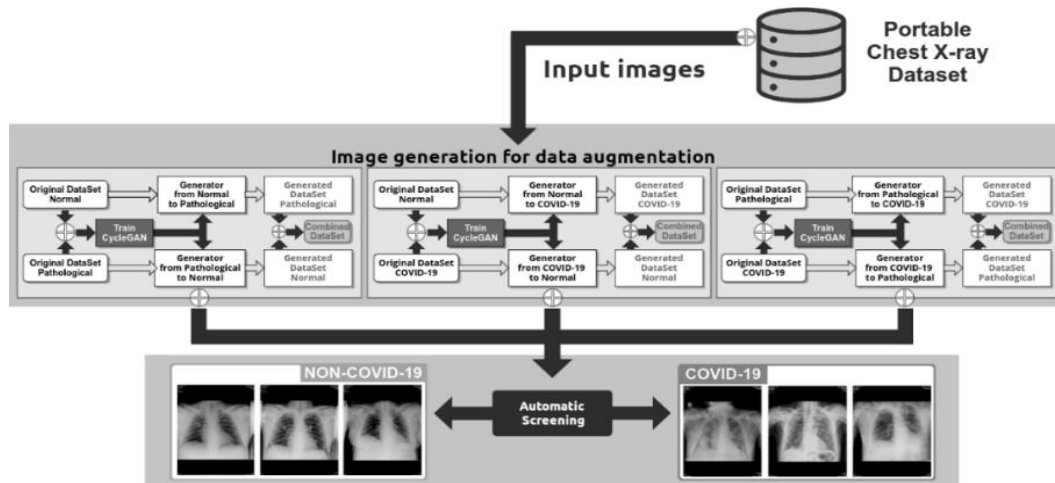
Overview of the methodology for data augmentation and COVID-19 screening using portable chest X-ray images. The first part performs the image generation while the second part performs the automatic COVID-19 Screening.
